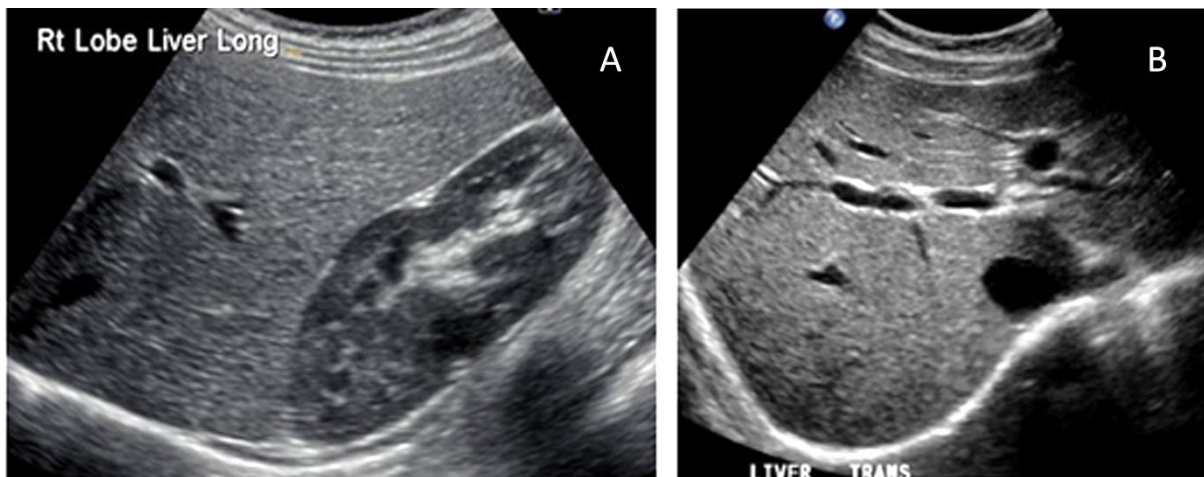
A: Right lobe of healthy liver (and kidney) B: Right lobe of liver (with portal vein), retrieved from www.ultrasoundpaedia.com
